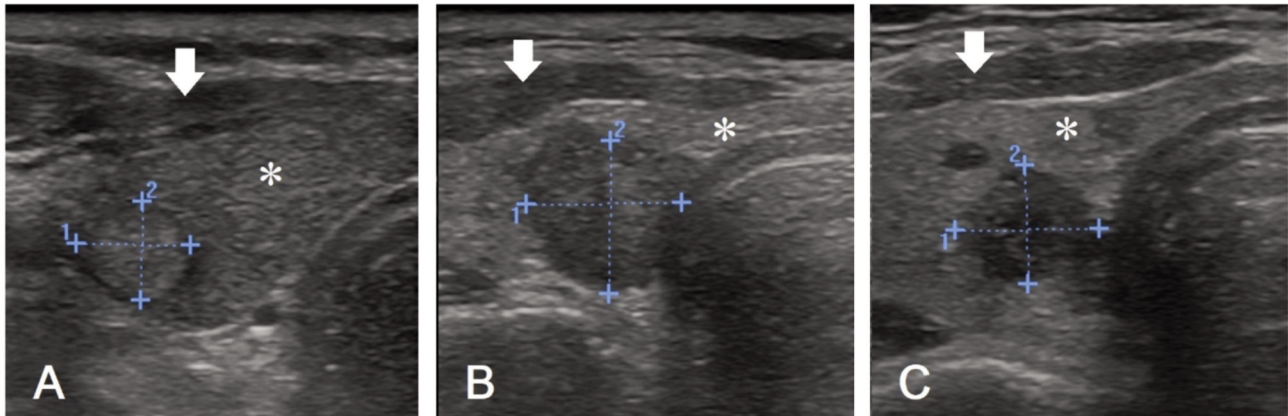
Three kinds of echogenicity demonstrated by ultrasound imaging. (A and B) The thyroid nodules (area defined by blue crosses) demonstrate the same echogenicity as the normal thyroid tissue (asterisks) (A) and the strap muscle (arrows) (B), which were recorded as isoechoic and hypoechoic. (C) The thyroid nodule with a well-defined spiculated margin in the right thyroid gland shows decreased echogenicity compared to the surrounding strap muscle (arrow), and it was recorded as marked hypoechoic.
